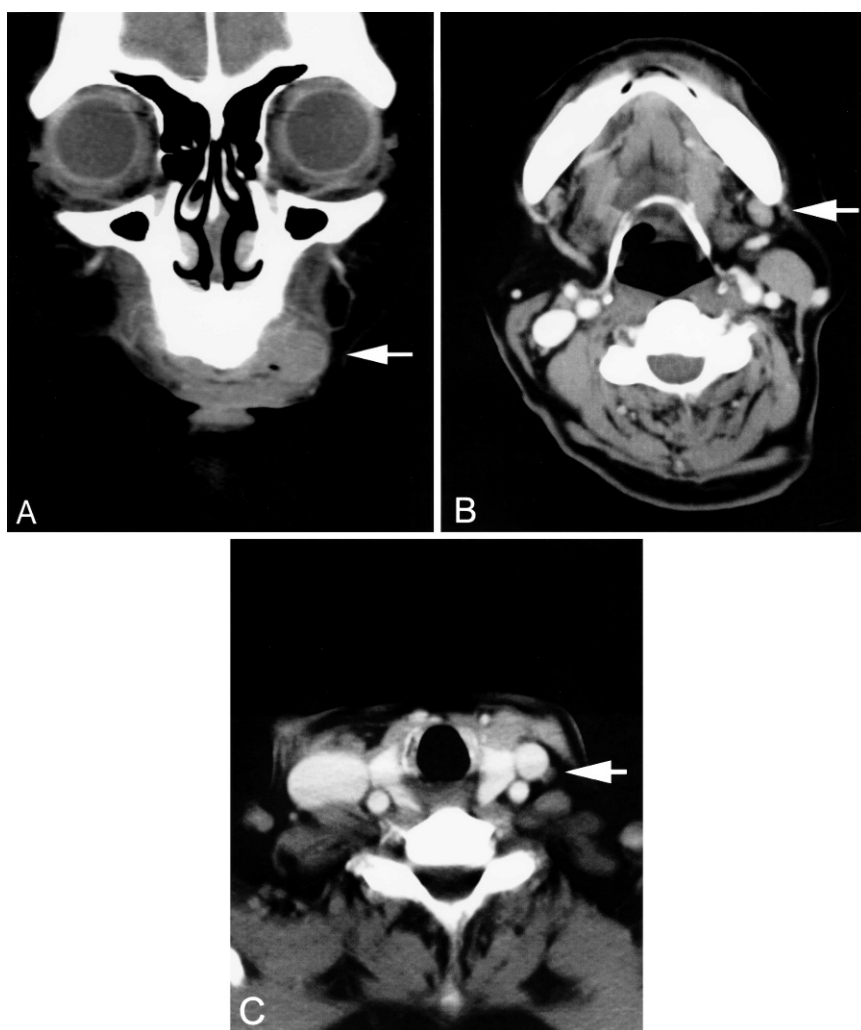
(A) Preoperative enhanced computed tomography image showing a 17×24 mm mass in the left maxillary gingiva (arrow; frontal section). (B) Preoperative enhanced computed tomography image showing a 10-mm lymph node in the left submandibular region (arrow; axial section). (C) Preoperative enhanced computed tomography image showing 8.3-mm lymph node in the left deep cervical region (arrow; axial section).
